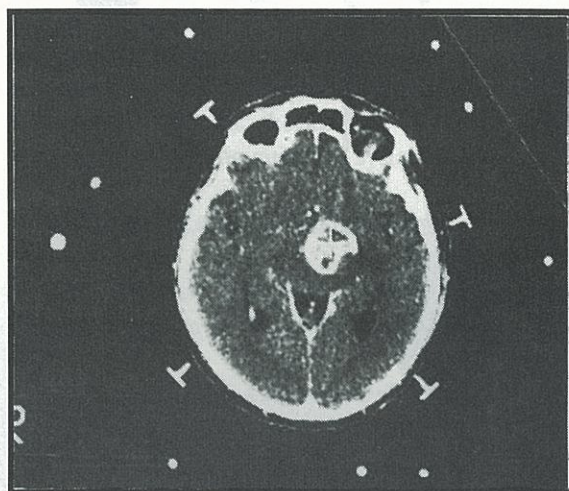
Artifacts on CT from localizing ring
